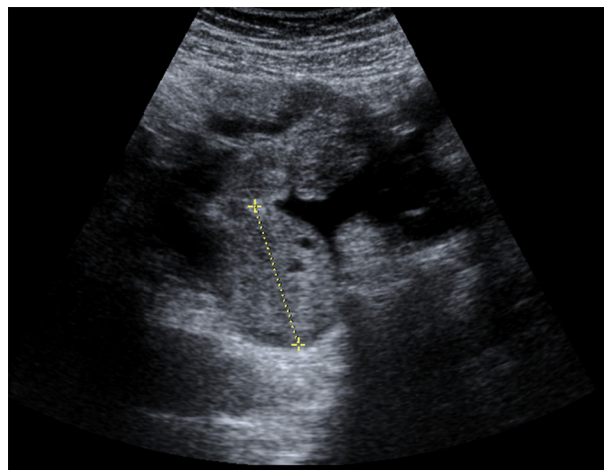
Ultrasound image showing an enlarged and echogenic mass in the pelvis.
